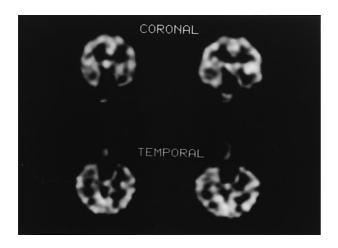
Tc-99m HMPAO SPECT images of an 8 year-old child with ADHD and oppositional defiant disorder and a scale of 37 for Du Paul teachers questionnaire rating in total show hypoperfusion in the bilateral temporal cortex and left frontal cortex. Hypoperfusion in the left medial temporal cortex is more marked than right medial temporal cortex.
